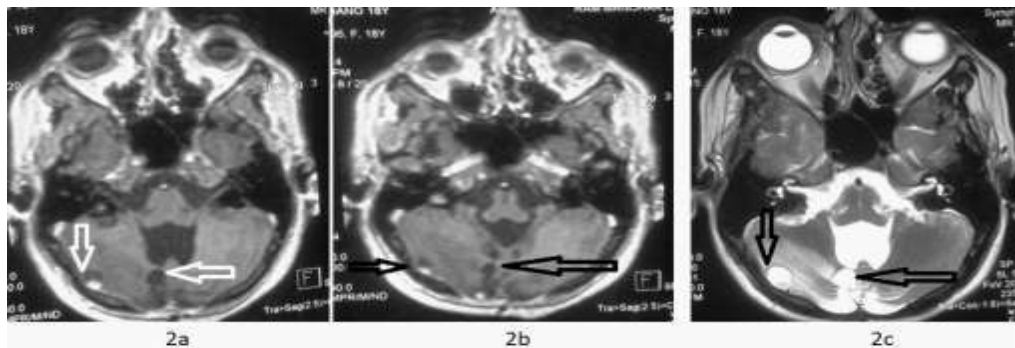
MRI Brain Axial sections. (a) Multiple enhancing hemangioblastomas in the cerebellum (white arrows). (b) Another section shows similar type of lesions (small black arrow). One of the small tumor has been surgically removed (large black arrow on left side). (c) T2W image show multiple hyperintense cystic components of the tumor (black wide arrows).
